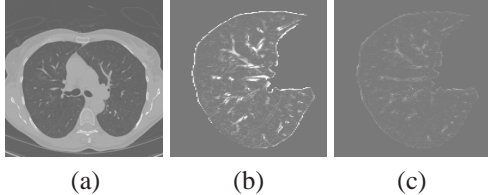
Improvement in registration by segmentation. (a) One slice of the follow-up scan CT volume of lung. (b) and (c) are the intensity difference maps between the transformed initial scan volume and the follow-up scan volume in the 1st and the 3rd iteration, respectively.
